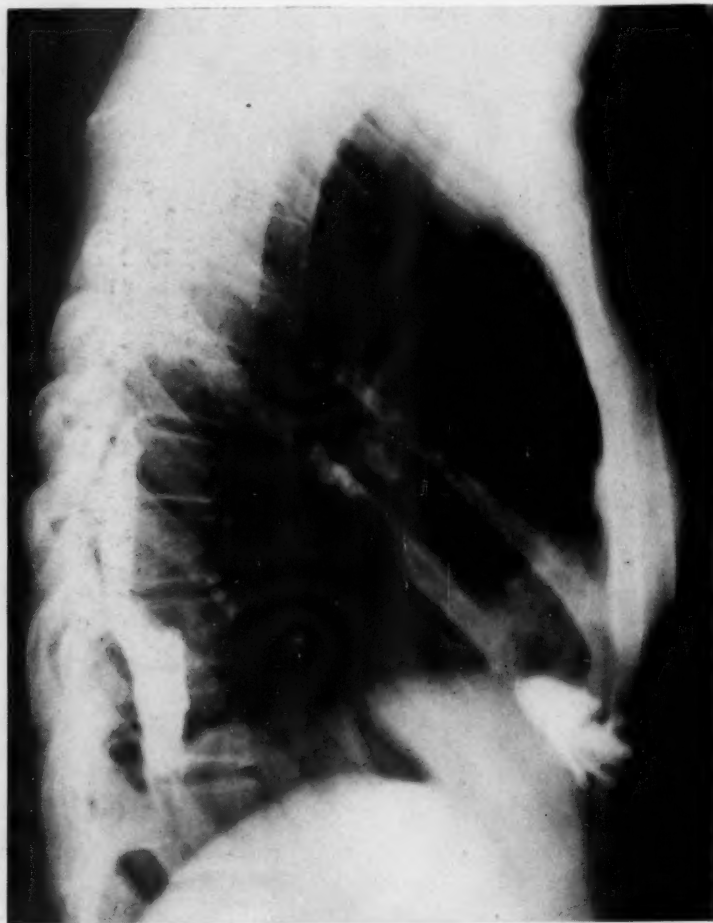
Case 12, Table II: Right lateral roentgenogram taken 45 days following drainage of the posterior pocket, and 37 days following the anterior; iodized oil has been injected into the sinuses.
